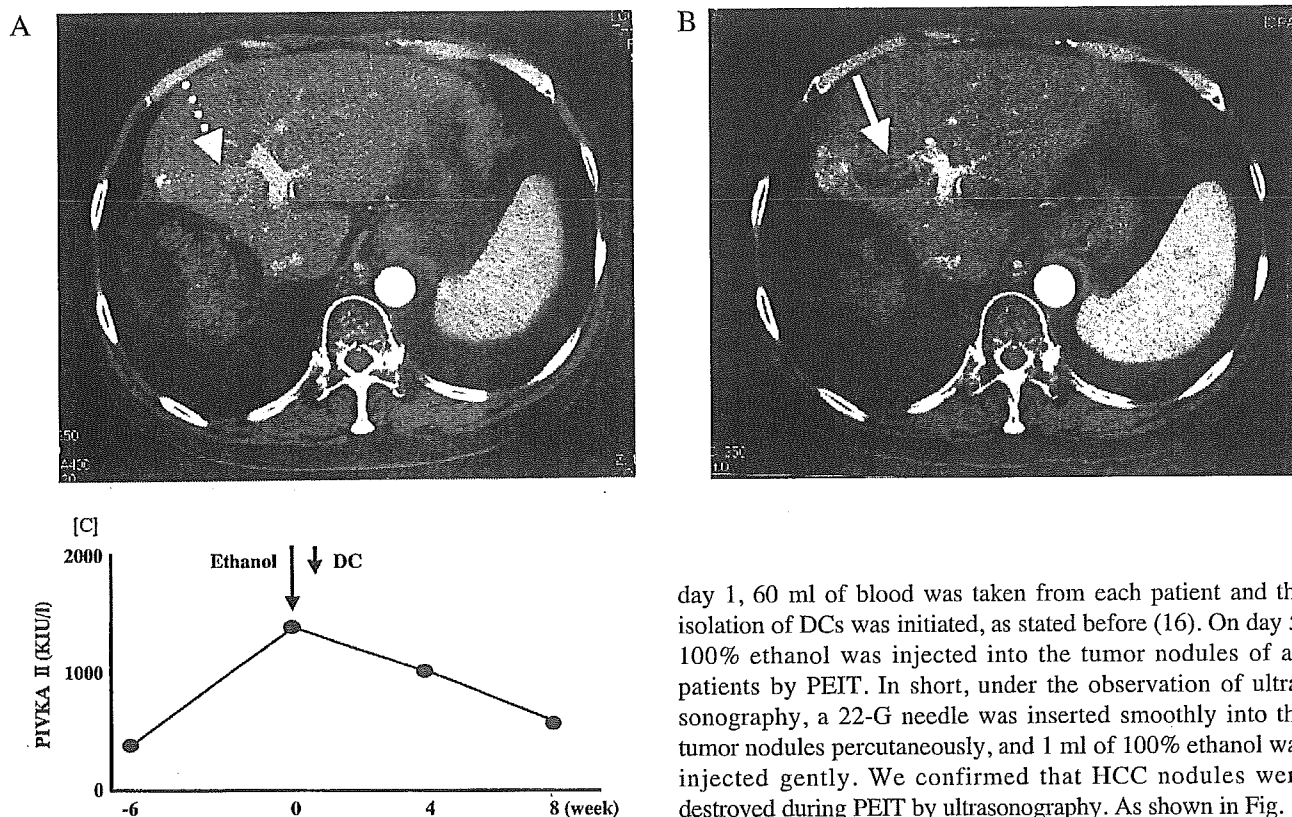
Enhancement in segment 4 of the liver on computed tomography of arterial phase (A, dotted arrow) altered to low-density area 2 weeks after the administration of DCs followed by the injection of only 1 ml of 100% ethanol in patient 3 (B, solid arrow). After the therapy, the level of PIVKA-II progressively decreased in this patient for the next 8 weeks (C).
